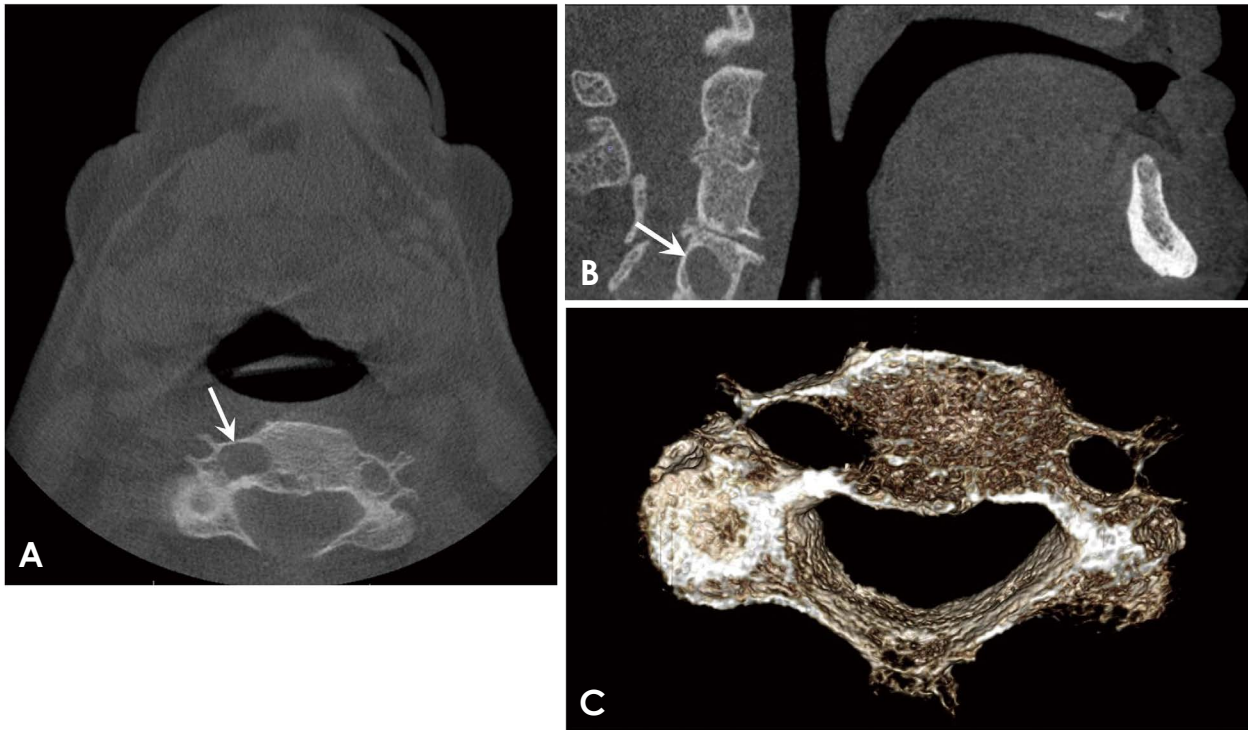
A. Axial cone-beam computed tomographic (CBCT) image at the level of C4 shows marked enlargement of the right foramen transversarium (arrow). B. Sagittal CBCT image shows smooth enlargement of the right C4 foramen transversarium with a well-defined margin (arrow). Degenerative changes of the cervical spine are also noted. C. Volumetric surface rendering CBCT image of the C4 vertebra with an enlarged right transverse foramen.
